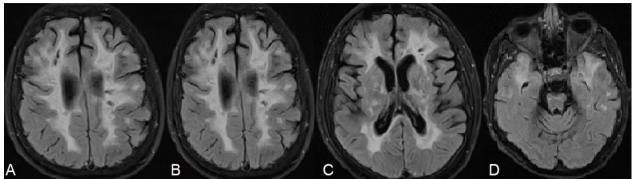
Brain MRI. Axial FLAIR images show advanced leukoencephalopathy and lacunar infarctions in the periventricular and the subcortical white matter and in the anterior temporal lobes, and brainstem atrophy.
